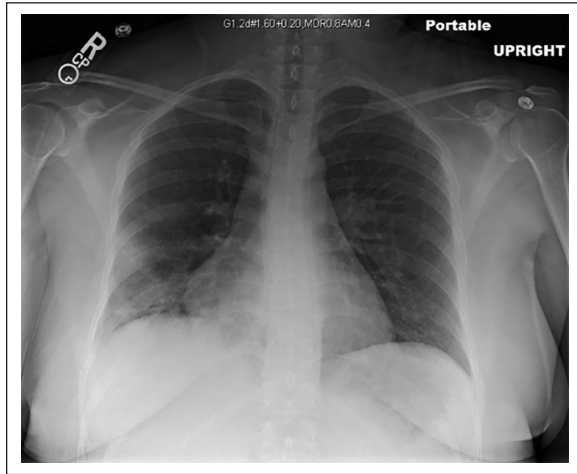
Chest x-ray of patient 2 with right middle to lower lung opacity.
